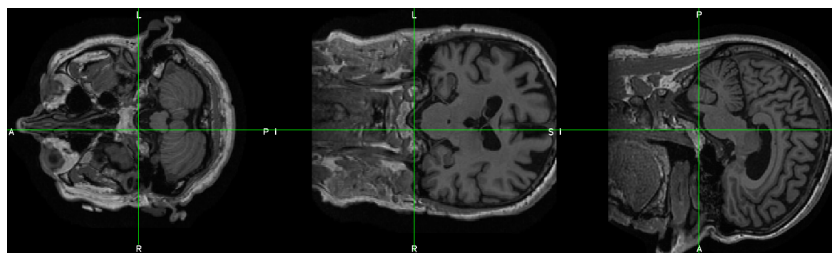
MRI scan of a MCI patient before applying BET.
